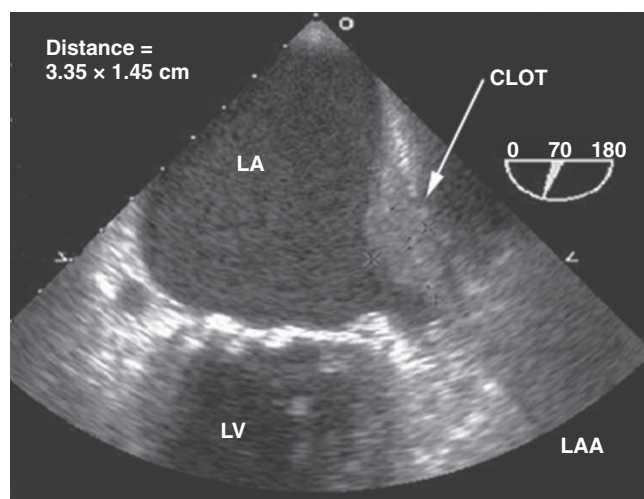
■ Large clot in the left atrial wall and left atrial appendage (LAA). A 72-year-old patient hospitalized in the ICU for urosepsis developed rapid atrial fibrillation. She was initially anticoagulated and rate-controlled. Despite resolution of the septic picture, she remained in atrial fibrillation 4 days after its onset. The patient underwent transesophageal echocardiography before undergoing a planned electrical cardioversion. The midesophageal view with multiplane transducer at 70 degrees revealed the presence of a large clot (3.35×1.45 cm) in the posterolateral wall of the left atrium (LA) extending into the LAA. With these findings, the patient's anticoagulation regimen was intensified, and the cardioversion was not performed. LV, left ventricle.
